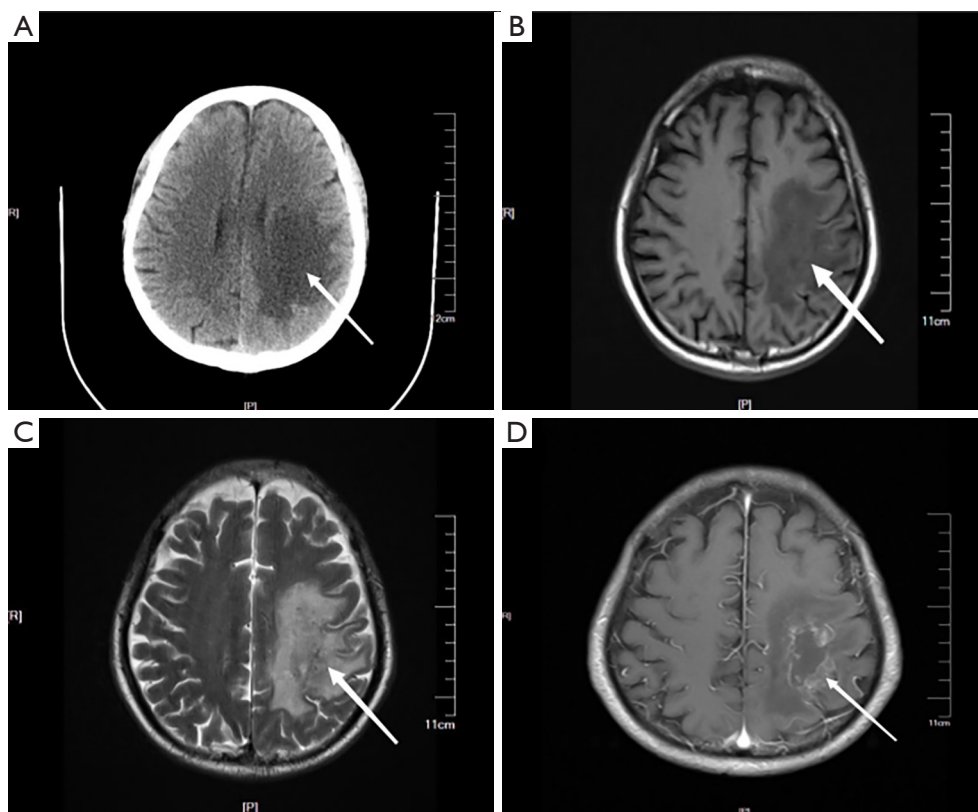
Brain CT scan and MRI of a patient with LM intracranial listeria infection complicated with brain abscess. Brain CT showed low density in the left frontoparietal temporal lobe, basal ganglia, and left cerebellar foot (A, arrow). MRI showed enhanced long T1 and long T2 signals (B,C, arrows), and shadow of ring enhancement in the same area (left frontoparietal temporal lobe, basal ganglia, and left cerebellar foot) (D, arrow). R represents the right side; P represents posterior side. CT, computed tomography; MRI, magnetic resonance imaging; LM, *Listeria monocytogenes*.
